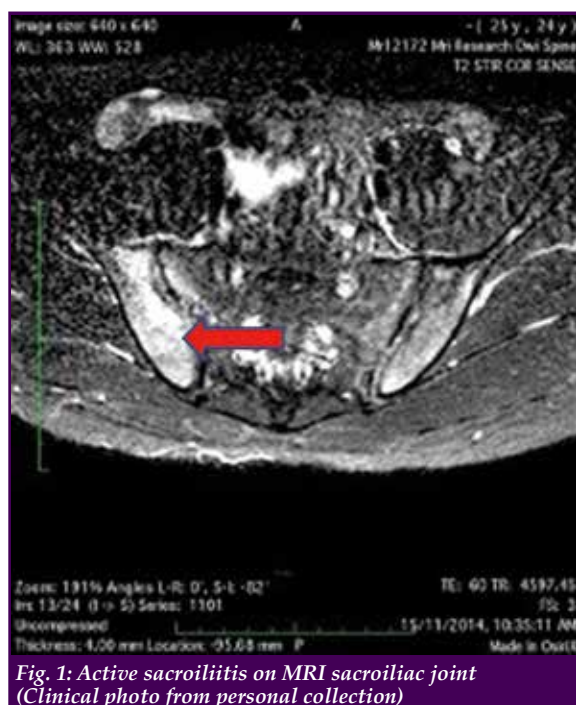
Active sacroiliitis on MRI sacroiliac joint (Clinical photo from personal collection)
